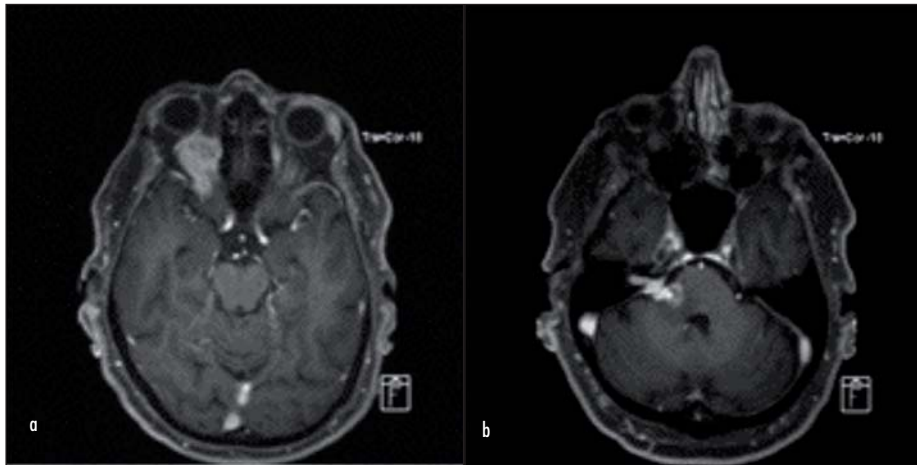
a. T1-weighted axial magnetic resonance imaging scan with gadolinium contrast shows a heterogeneous, enhancing right retrobulbar mass with extensive perineural involvement of the right ophthalmic branch of the trigeminal nerve. Some cystic degeneration is seen. b. Perineural invasion of the right facial nerve is demonstrated on this further axial magnetic resonance imaging scan, showing an enhancing mass in the right cerebellopontine angle, extending into the adjacent pons and right internal acoustic meatus.
